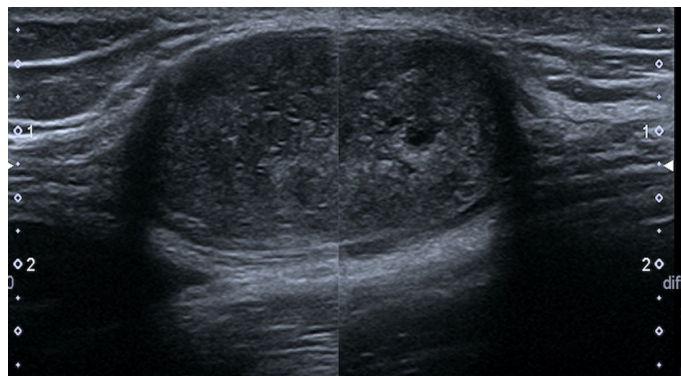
Sonographic imaging of Schwannoma associated to median nerve.
